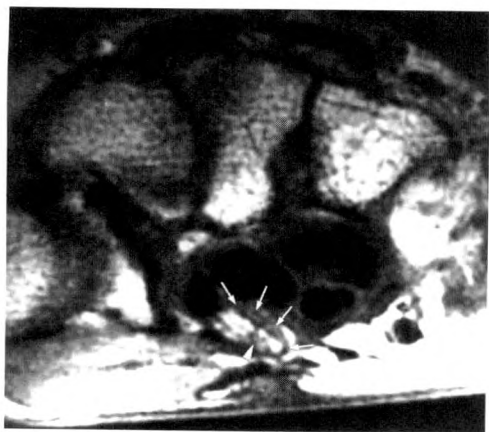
Distortion of median nerve in patient with recurrent carpal tunnel syndrome after flexor retinaculum release. Axial MR image (TR 500, TE 25) showing flattened median nerve (arrows), which is distorted by small soft-tissue mass (arrowhead). Note absence of normal flexor retinaculum secondary to prior surgery. Left wrist viewed toward elbow with palm down.
